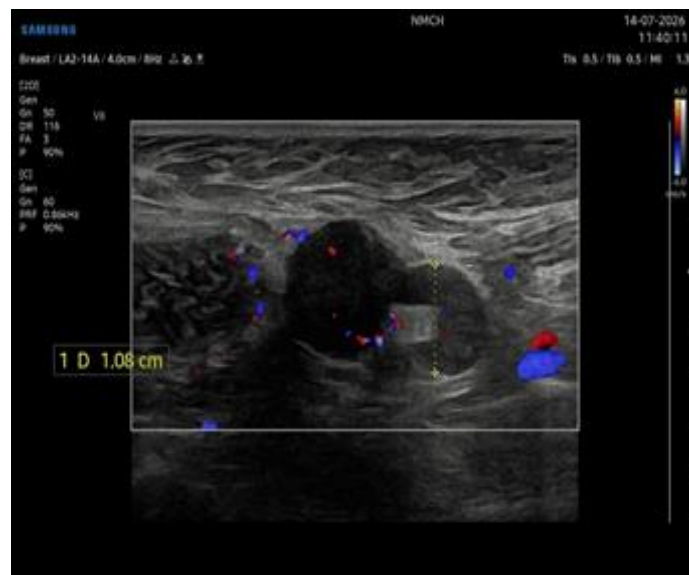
Color Doppler ultrasonography of the left axilla demonstrating an enlarged axillary lymph node with cortical thickening, increased vascularity, and loss of the normal fatty hilum, suspicious for metastatic nodal involvement.
